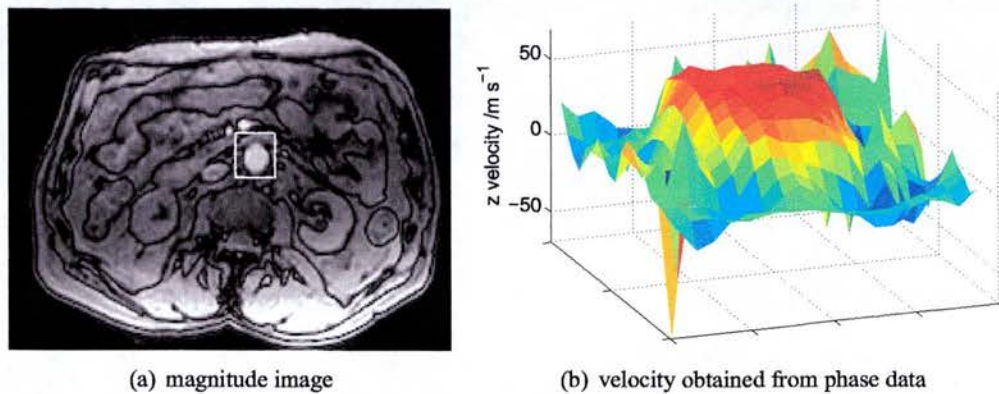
Phase contrast MRI measurement of z -component of velocity in the aorta.
